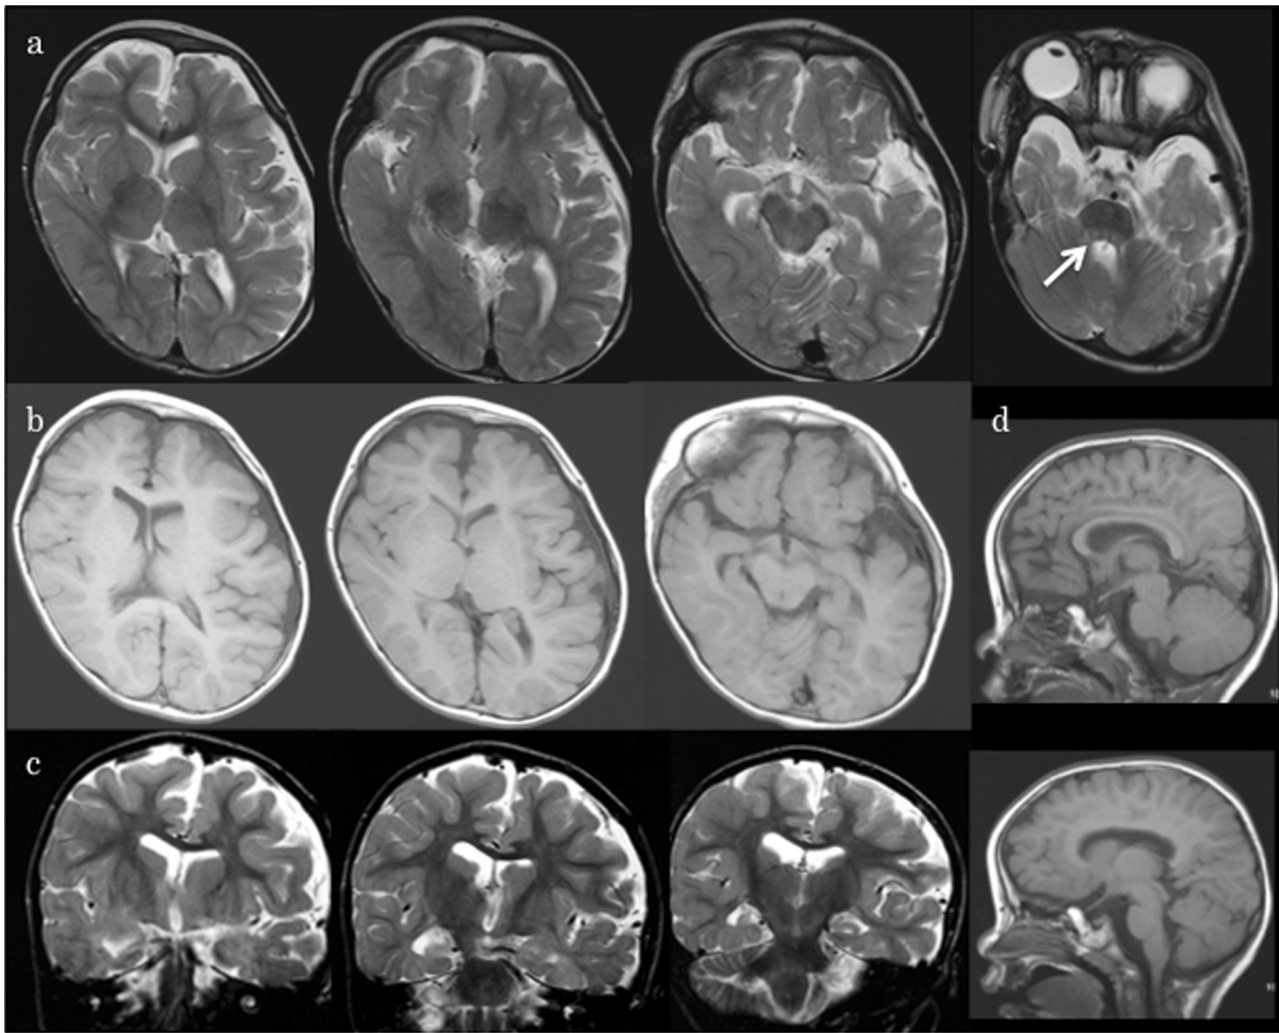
Brain MRI at 3 years old, axial T2WI (a), FLAIR (b), coronal T2WI (c), and sagittal T1WI (d). Asymmetric basal ganglia and lateral ventricle are indicated. High intensity of the central tegmental tract on T2WI was shown with white arrow. He had no midbrain-hypothalamus dysplasia. The infratentorial structures, optic nerve, and corpus callosum are considered as normal
